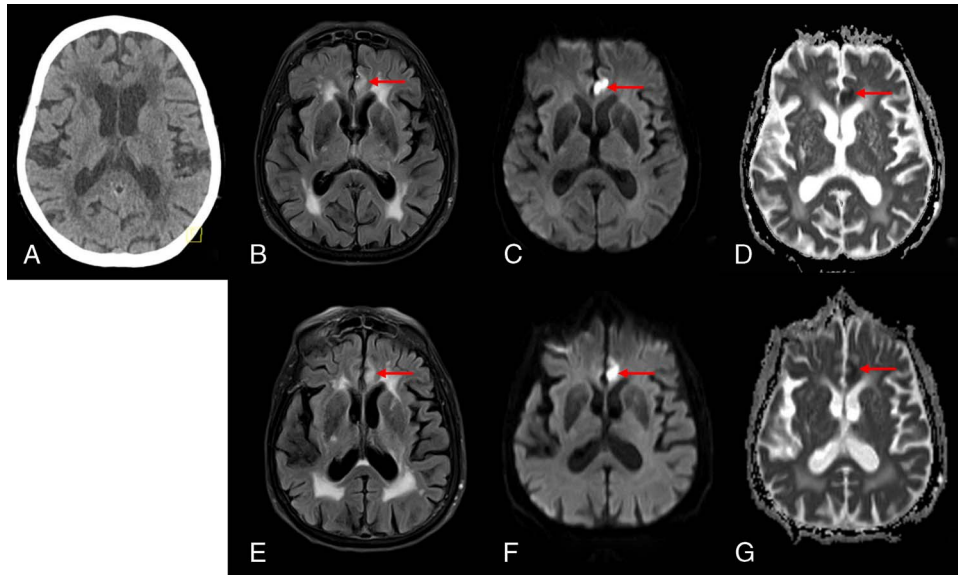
CT-occult subacute ischemia (left gyrus cinguli). Axial noncontrast head CT (A), fluid-attenuated inversion recovery (FLAIR) (B and E), diffusion-weighted imaging (DWI) (C and F), ADC-map (D and G) from the standard-length protocol (top row) and ultrafast-MRI (bottom row) in an 83-year-old woman with known epilepsy presenting with somnolence. The noncontrast head CT showed no evidence of ischemia or hemorrhage. Magnetic resonance imaging demonstrated a small subacute ischemic lesion in the left gyrus cinguli (arrow). Ultrafast-MRI demonstrated noninferior image quality and lesion conspicuity compared with the standard-length protocol.
